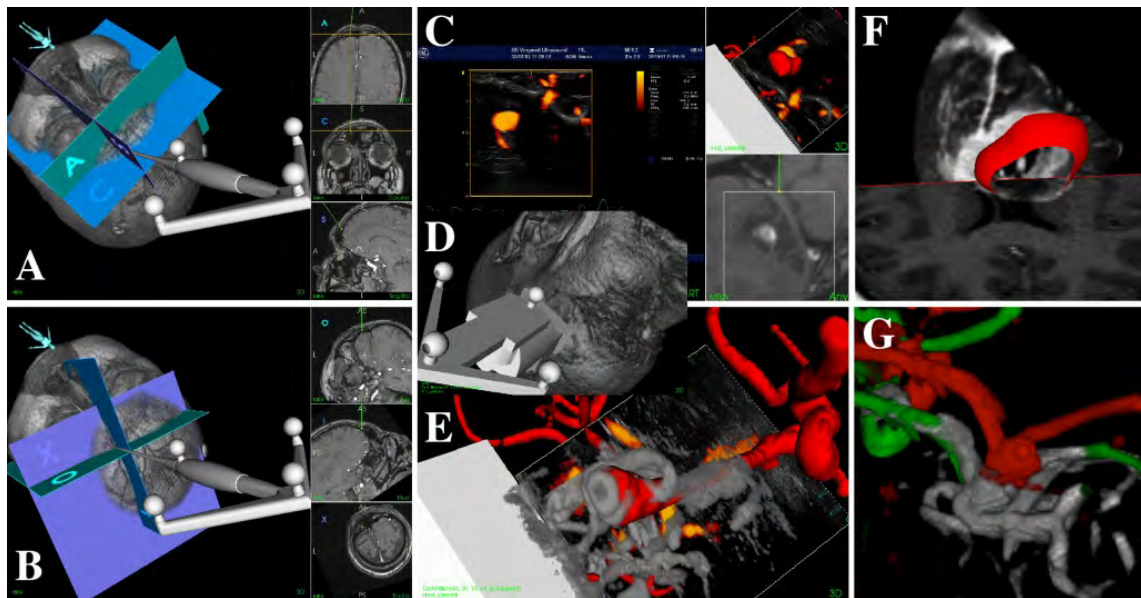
Multimodal visualization. Orthogonal (A) and oblique (B) slicing, the position as well as the position and the orientation of the tool are used to extract the slices respectively. The three basic visualization types are shown in each image. The head is volume rendered in a 3D view that also shows geometric representations of both the tool and slice indicators. Corresponding slices are shown in a 2D view at the right. C) Display during freehand 3D ultrasound acquisition: Real-time 2D ultrasound to the left and an indication of the us-scanplane relative to MR data in a 3D and 2D view to the top and bottom right respectively. D) Overview of probe relative to head. E) Detailed view of real-time 2D ultrasound relative to MRA (red) and 3D power Doppler data (gray). F) Slice from ultrasound (top part) and MR (bottom part), surface model in red from MR (middle part). Mismatch between US (slice) and MR (tumor model) is clearly visible. G) 3D ultrasound (gray) is used to correct MRA (moved from red to green position) during an aneurysm operation.
